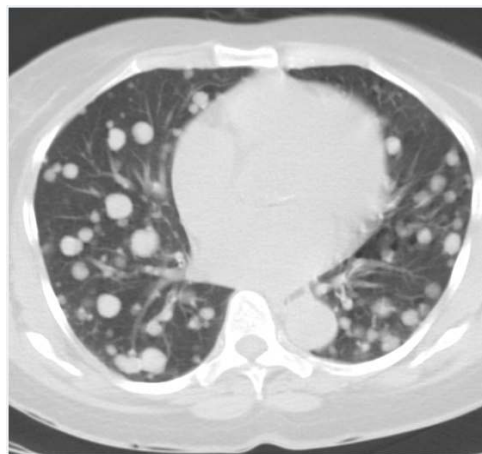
Computed tomography image of the thorax showing multiple “cannon ball” lesions of suspected lung metastasis
